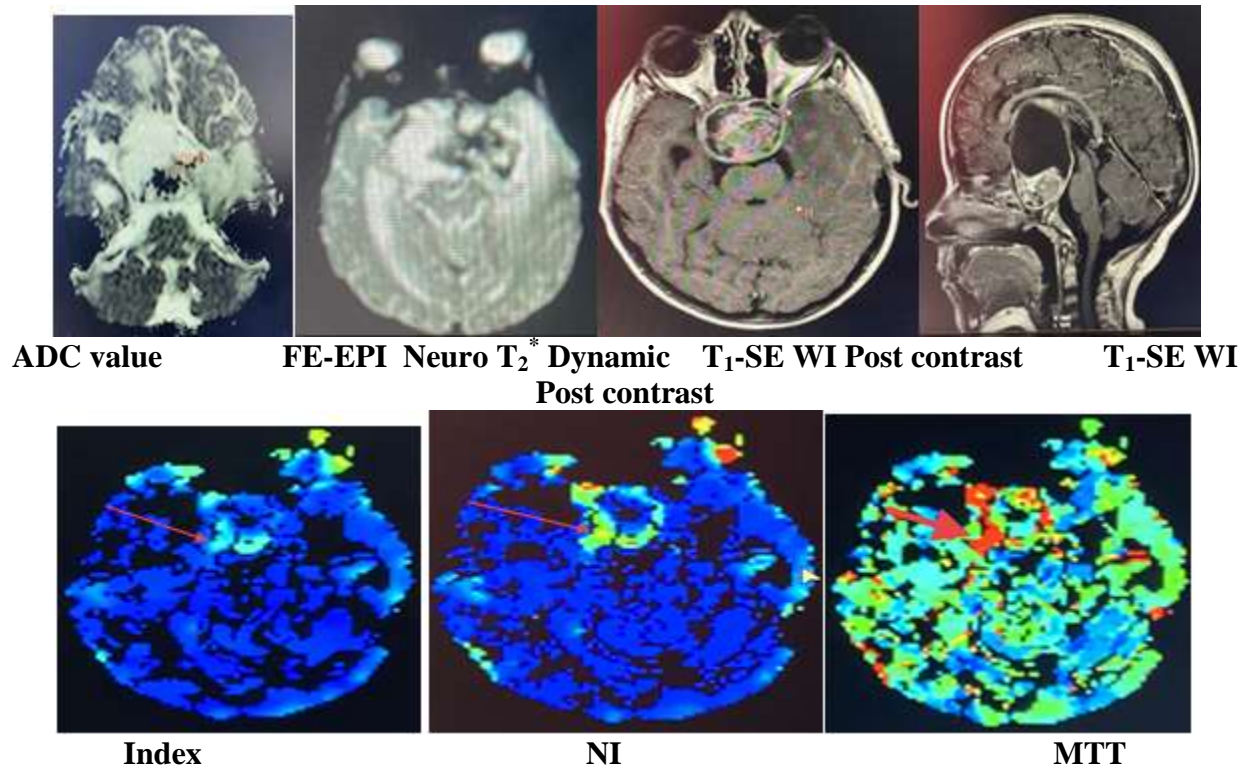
Image that shows MRI of the brain tumors with craniopharyngioma
